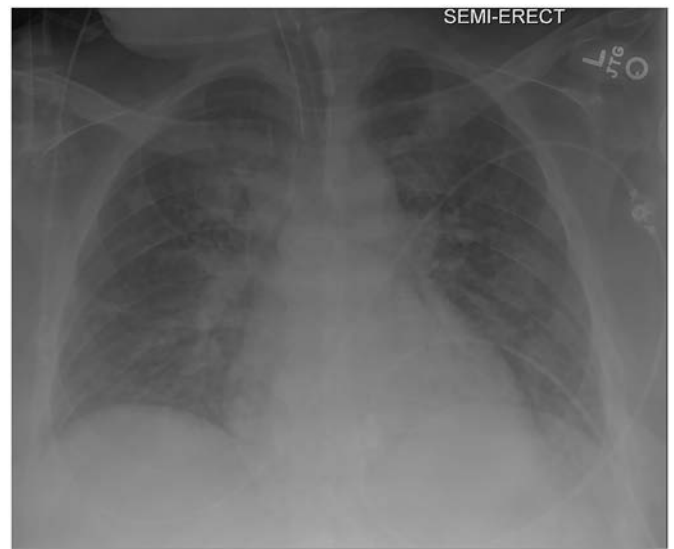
Anteroposterior chest radiograph demonstrating bilateral interstitial infiltrates without consolidation.
